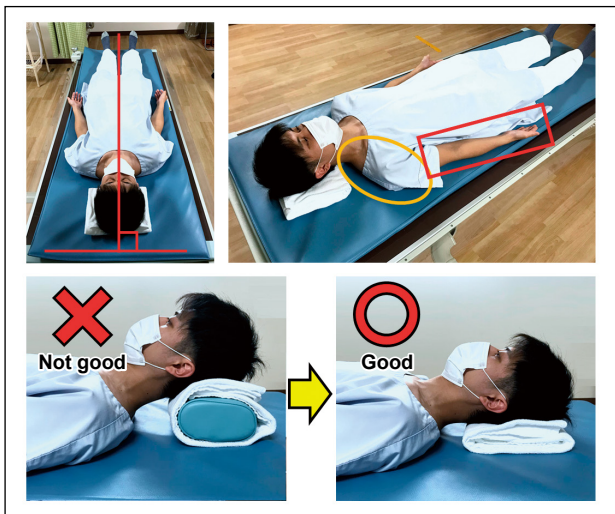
Positioning Measures for Supine Radiography
